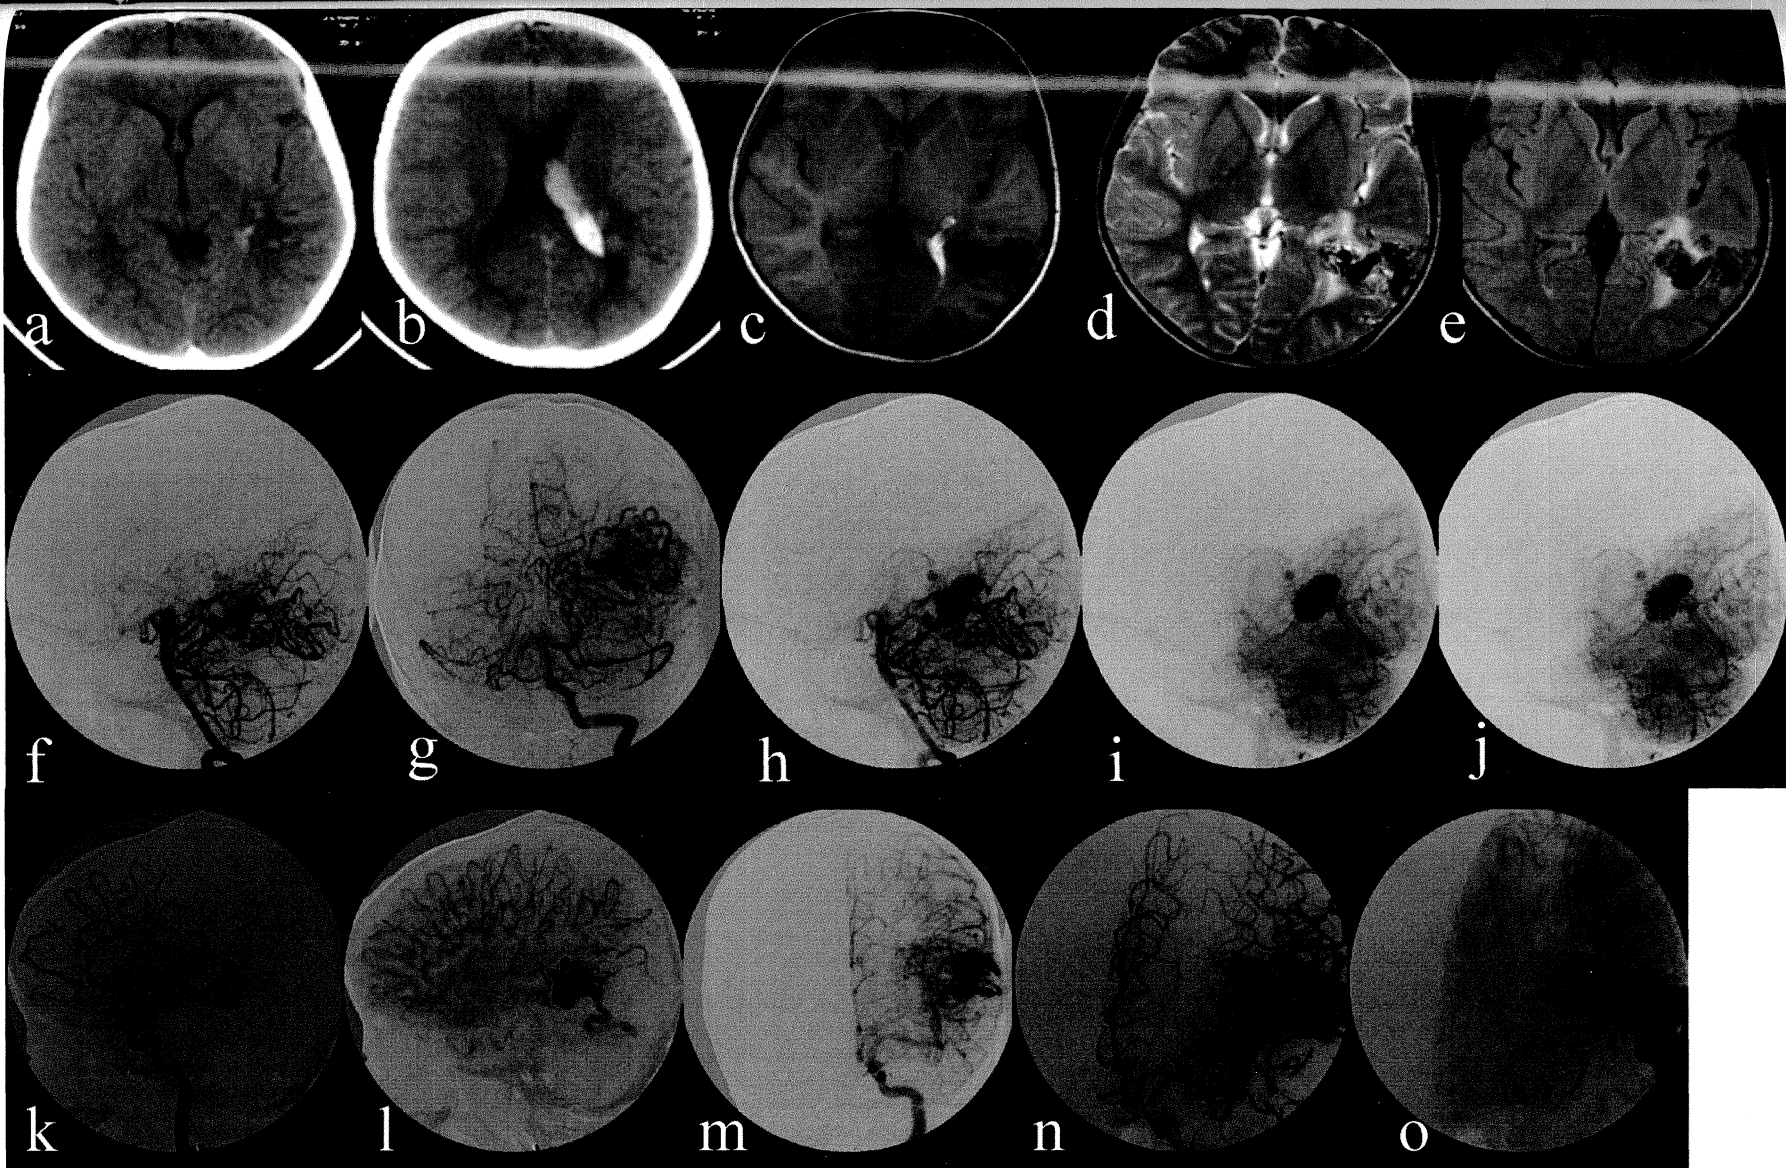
7 year old child presented with sudden fall followed by holocranial headache and vomiting. CT (a, b) and MRI (c-e) revealed left temporo-parieto-occipital gliosis with prominent draining vein and intraventricular hemorrhage. DSA (f- o) showed a moderate sized AVM fed by Left MCA and PCA draining into a large venous sac and straight sinus. Suspicious small intranidal/perinidal aneurysm noted.
